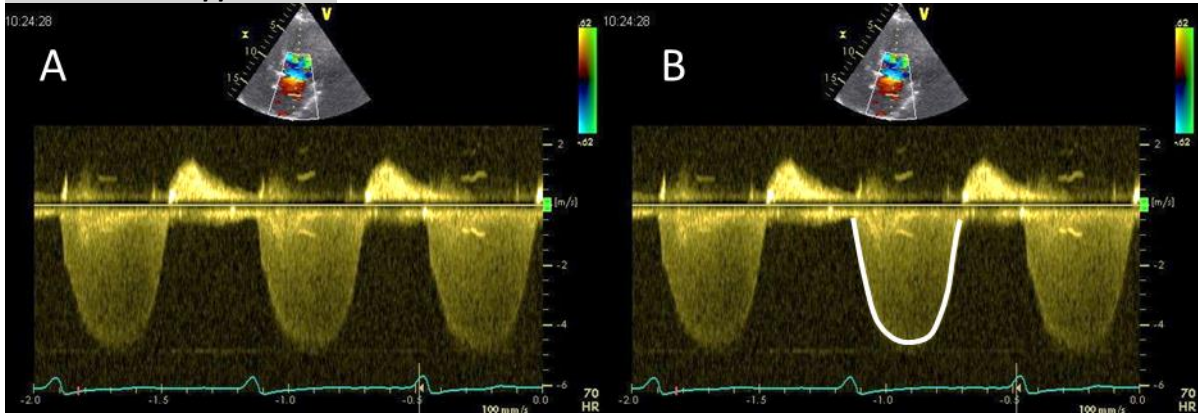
CW Doppler MV (A) and measurement of MV insufficiency jet (B)
